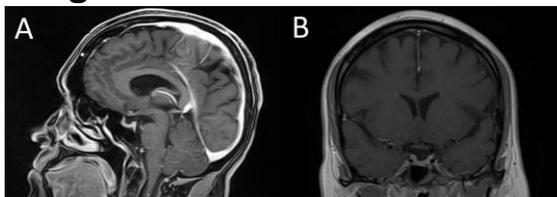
Sagittal post contrast T1-weighted sequence (A) and coronal T1-weighted sequence performed before the lumboperitoneal shunt.
